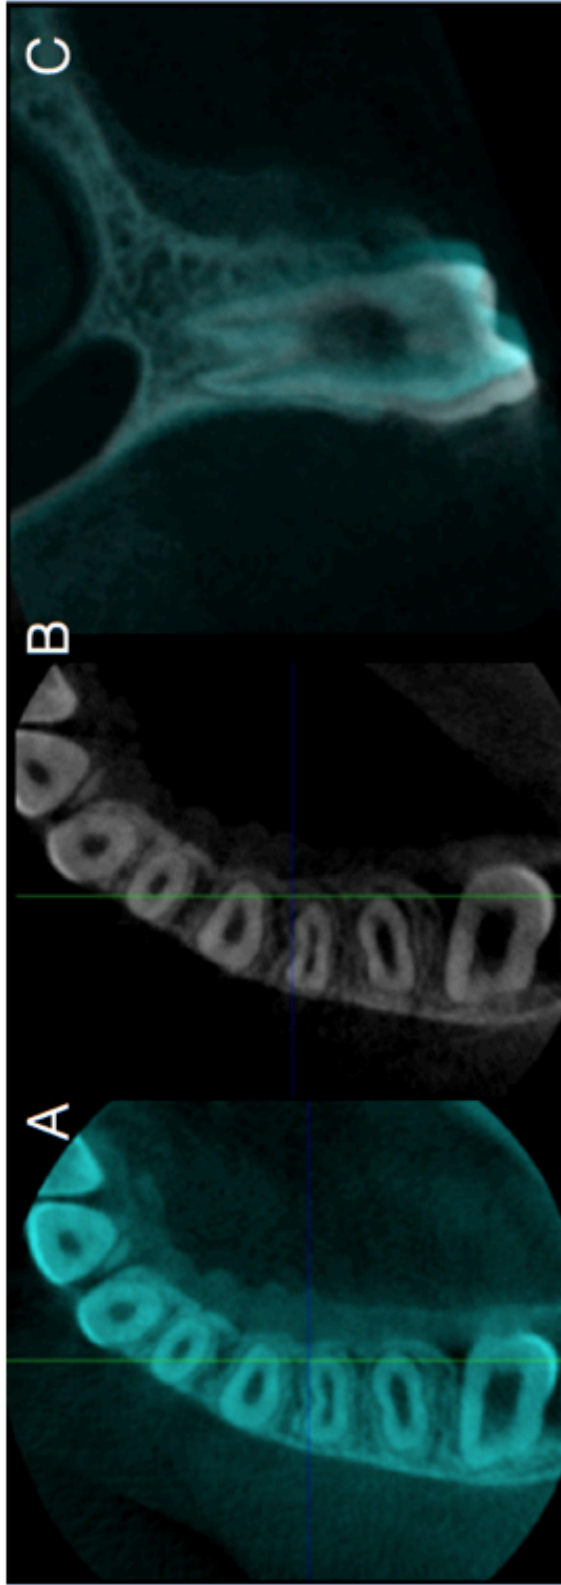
Images from the 3D superimpositions of patient 13: Patient 13 represents a patient with an average amount of tooth movement. White is the final position and green is initial. A. Coronal view of pre-treatment CBCT images. B. Coronal view of post-treatment CBCT image. C. Frontal view of superimposed 3D CBCT images.
